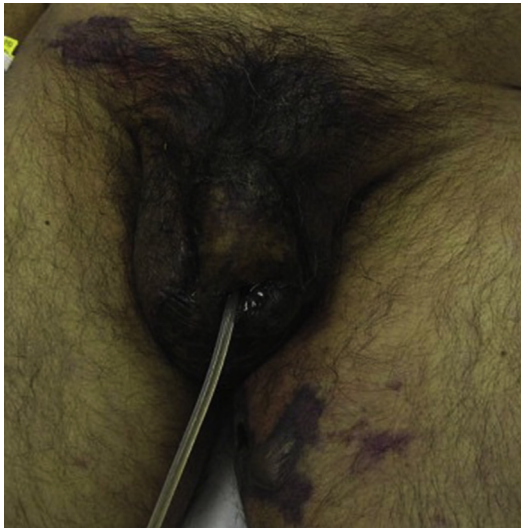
Fournier gangrene demonstrating expanding necrotic tissue involving the genitalia, right inguinal region, and left inner thigh. (From Kim DJ, Kendall JL. Fournier's gangrene and its characteristic ultrasound findings. *J Emerg Med* 2013;44(1):e100; with permission.)
